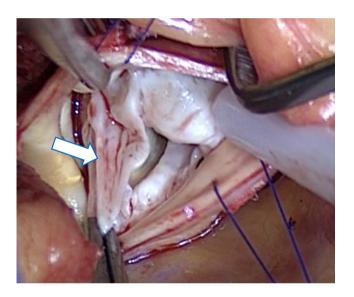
Intraoperative image of the aortic valve. Intraoperative findings of the unicuspid valve, which exhibited a single commissure. The arrow indicates the redundant lesion of the aortic valve, which was recognized as a mobile mass by transesophageal echocardiography (TEE).
